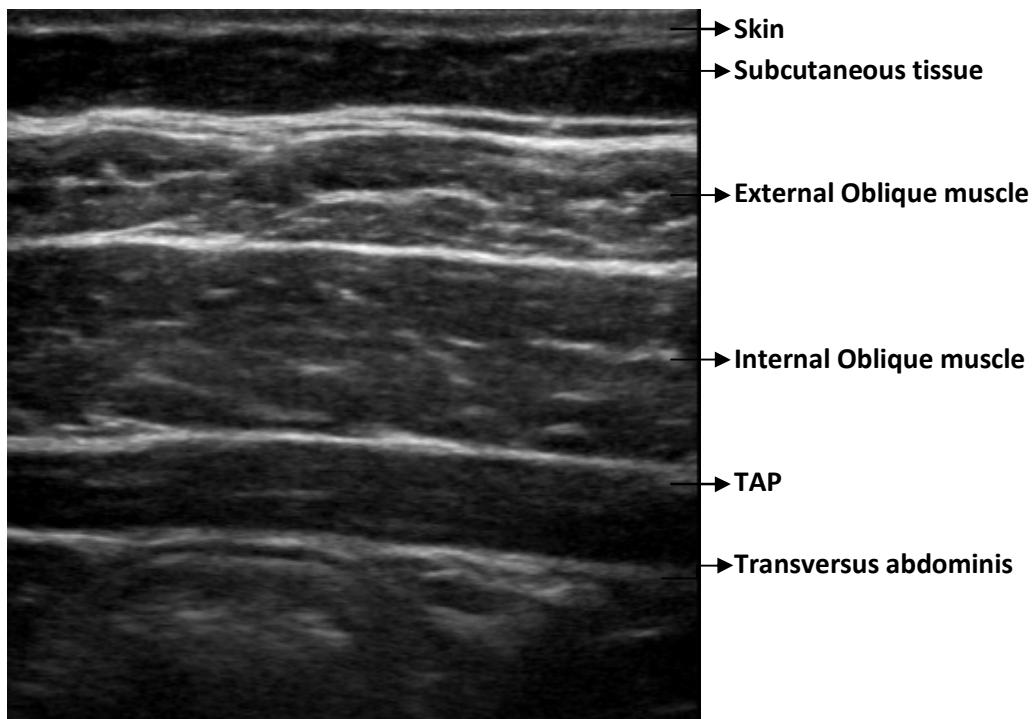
Ultrasound anatomy of TAP block
